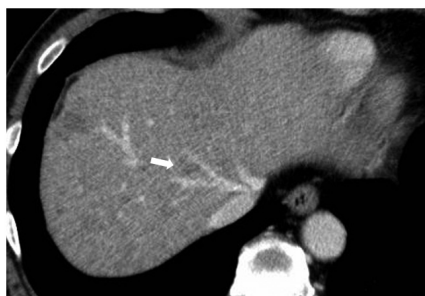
Preoperative CT scan in Case 1. The arrow points to a low-density nodule that was suspected of being a tumor preoperatively.
